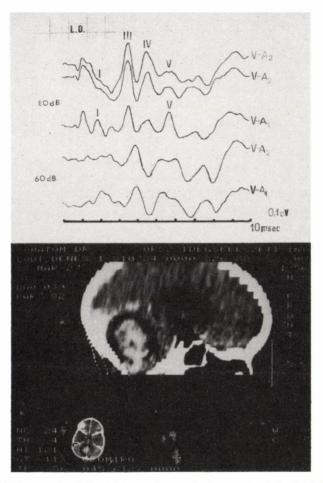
BAEP and CT scan in a 6.5-year-old child with left cerebellar astrocytoma $$V\!-\!A_2\colon right side: wave V. depressed, III./V. increased
